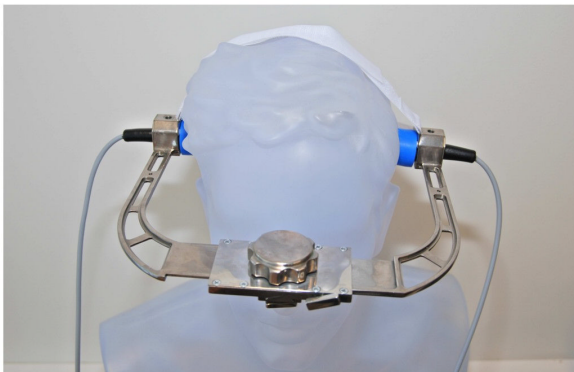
Mechanical frame for affixing of ultrasonic transducers on the human head
